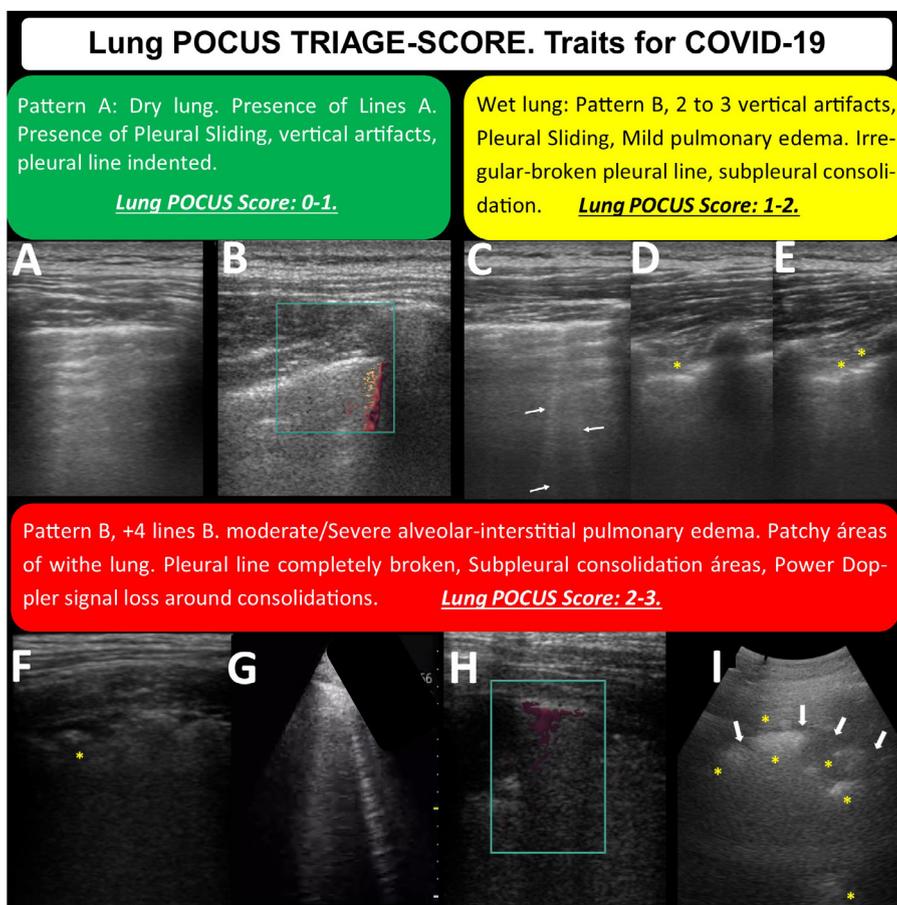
Intuitive triage point-of-care ultrasound (POCUS) protocol for patients suspected or confirmed to have COVID-19. Classifications of pleural lesions and POCUS scores. Asterisks indicate an indented and ruptured pleural line (c–e). Multiple subpleural consolidations and a broken pleural line are seen (f, h, i). Multiple diffuse B-lines (vertical artifacts) are visible that start from the irregularity of the pleural line (c), a pattern of multiple vertical artifacts in a subpleural consolidation (g, h). All findings are from the middle and inferior areas from the posterior thorax.
